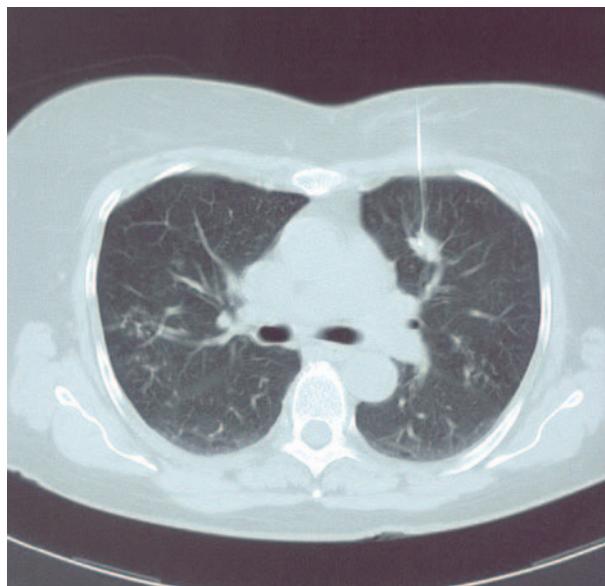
CT-guided positioning of the hooked wire; CT-scan thorax.*
